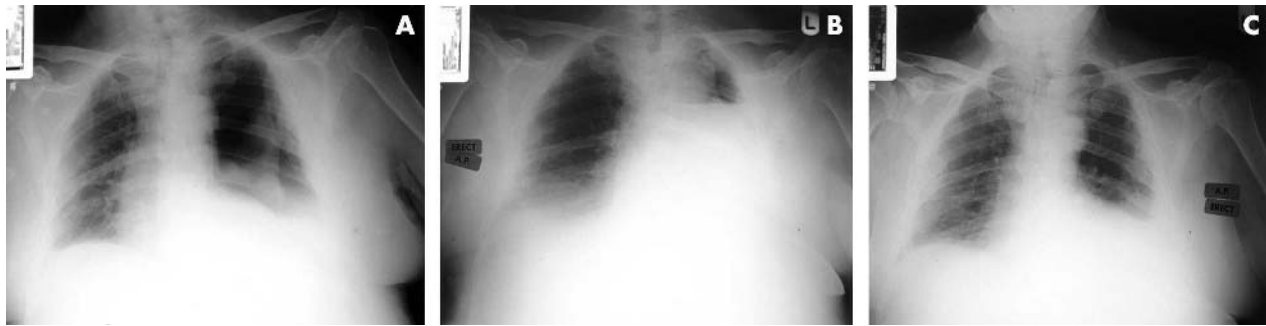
Anteroposterior radiographs: (A) first, (B) second, (C) third.
